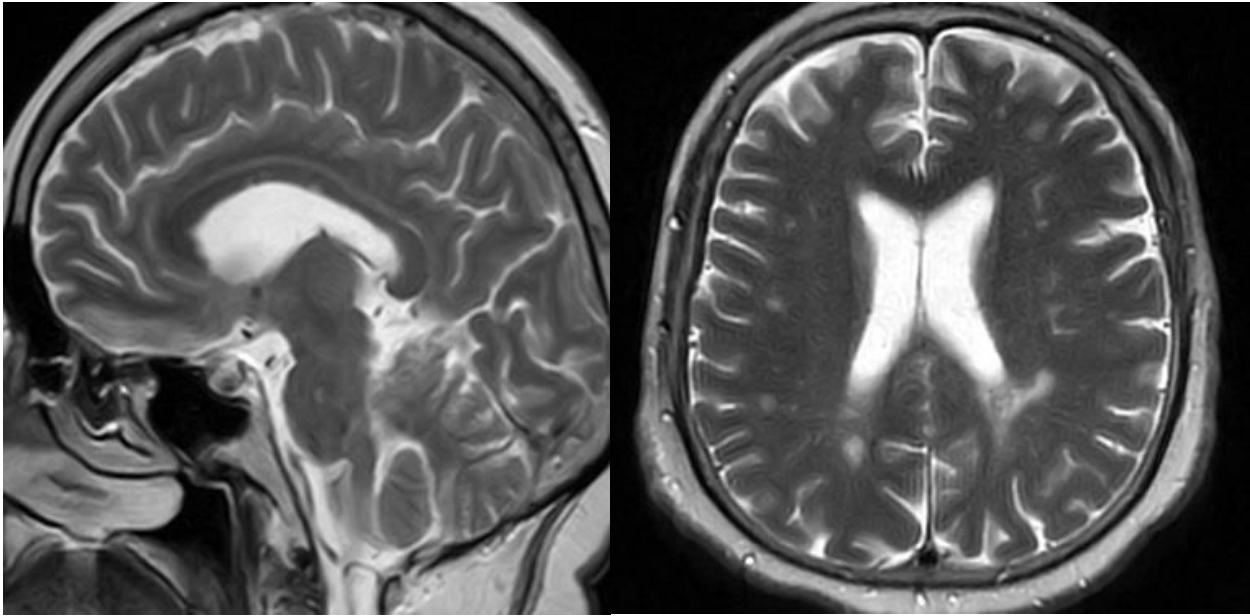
MRI in the sagittal and frontal planes revealed data for a focus of pathological MR signal intensity in the parenchyma of the medulla oblongata; single foci of glial changes in the parenchyma of the frontal and parietal lobes of the cerebral hemispheres. Initial manifestations of dyscirculatory encephalopathy.
